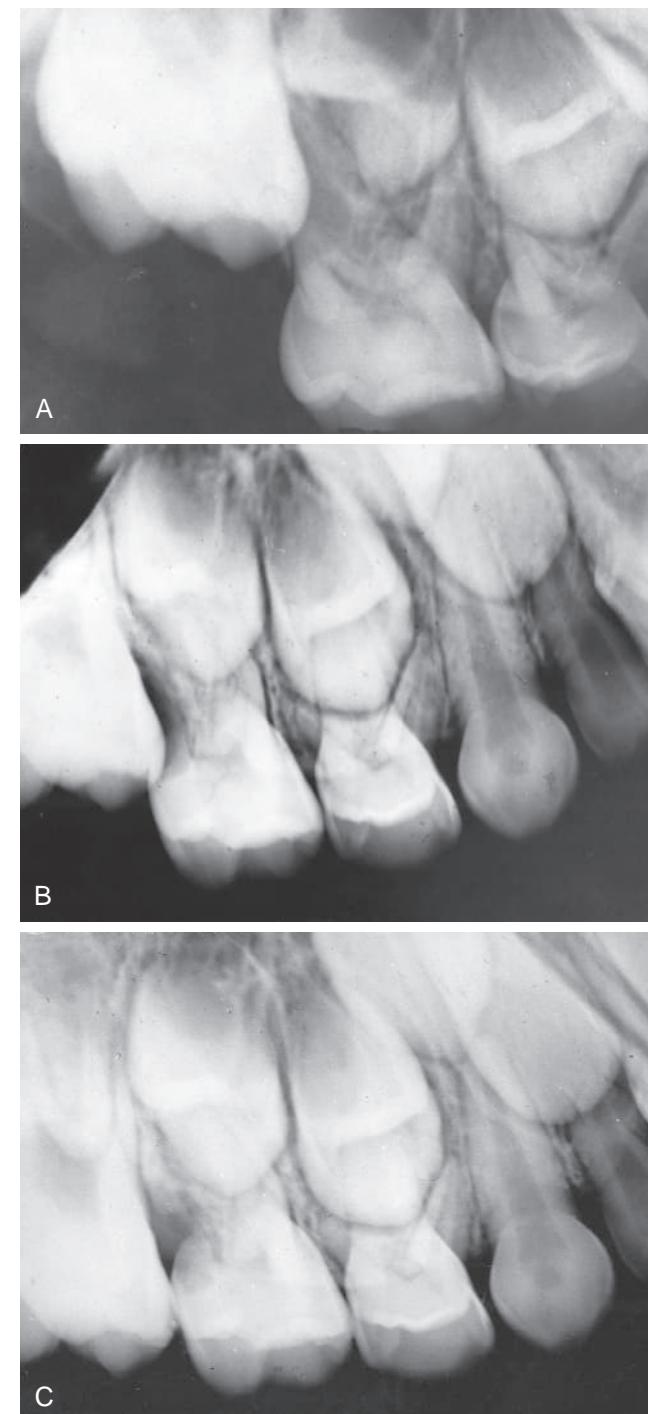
(A) Ectopic eruption of a maxillary first permanent molar with evidence of resorption of the distal buccal tooth of the second primary molar (B) and (C) Subsequent radiographs show continued resorption of the primary molar but “self-corrective” eruptive positioning of the first permanent molar. Approximately two-thirds of ectopic molars are reported to exhibit such a “reversible” pattern.
